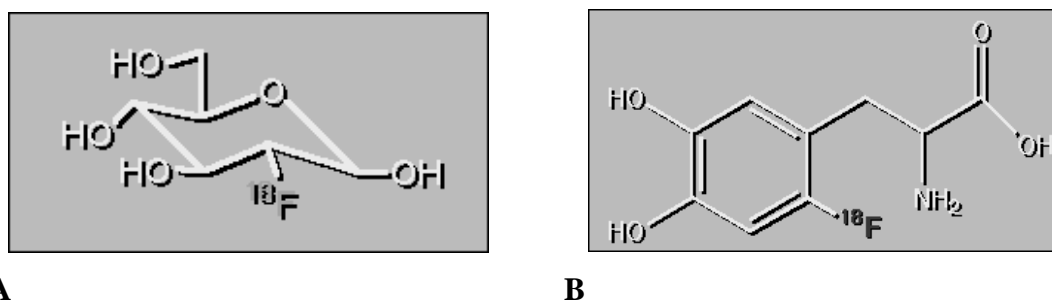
The radiopharmaceutical compounds ^{18}F -FDG (A) and ^{18}F -DOPA (B).
